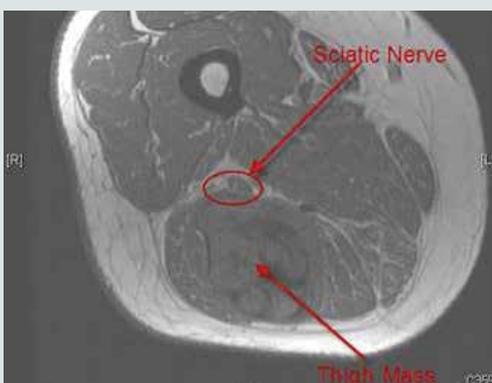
T1 weighted axial MRI demonstrating a significant reduction in the size of the posterior thigh mass. The sciatic nerve remains close but not directly involved with the tumor.
